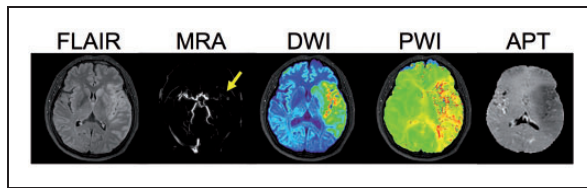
Multi-parameter MRI in an acute stroke patient with left MCA occlusion at 6 h 40 min after last seen normal. FLAIR (T₂-weighted image with CSF suppression) image shows some early vasogenic edema outlining the cortex, while DWI hyperintensity shows a larger region with cytotoxic edema. The PWI (relative bolus transit time in this image) shows a large hypoperfusion region and the APT image shows a large area of reduced pH effect (hypointensity) that is larger than the hyperintense region on FLAIR and similar in size approximately to the ADC, but smaller than the area affected in PWI, suggesting minimal penumbral tissue but areas of benign oligemia. (Reproduced in part, with permission, from Heo HY et al. unpublished data).
